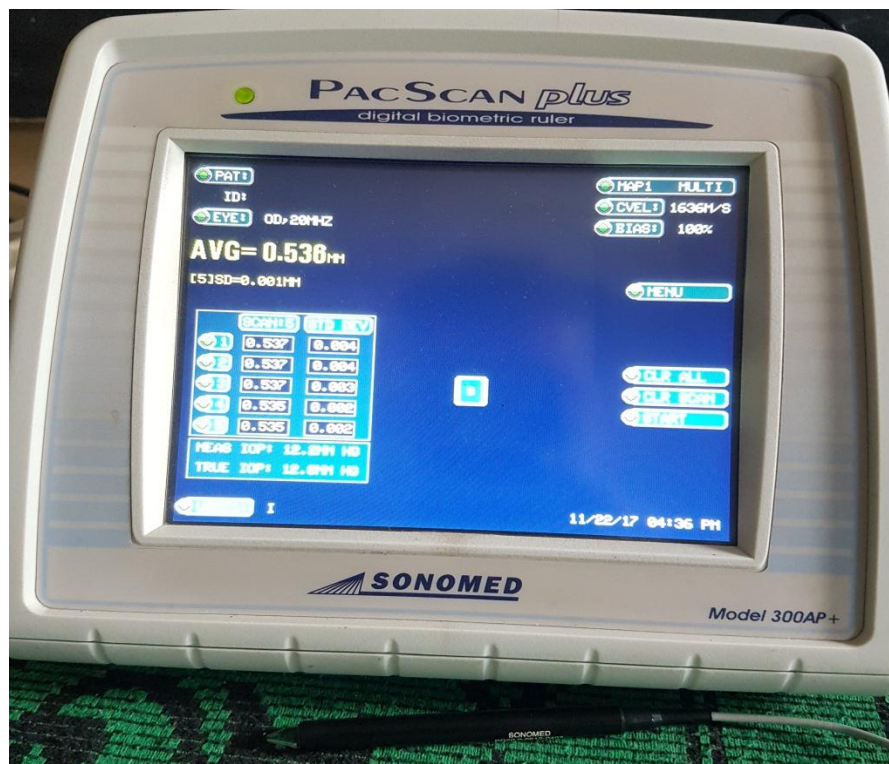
Measurement of Central Corneal thickness by Ultrasound Pachymetry
